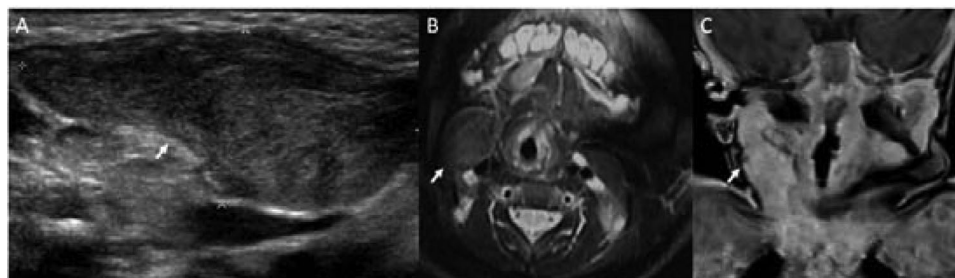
Sagittal US image (A), axial fat-suppressed T2-weighted (B), and coronal contrast-enhanced fat-suppressed T1-weighted (C) MR images of a child with *Fibromatosis colli*. The ultrasound image (A) demonstrates heterogeneous hyperechoic fusiform enlargement of the caudal part of the sternocleidomastoid muscle. A rim of normal peripheral muscle is shown. The axial MR image (B) reveals mild increased T2 signal intensity of the sternocleidomastoid muscle as well as mass effect on adjacent structures. The sagittal MR image (C) demonstrates contrast enhancement of the sternocleidomastoid muscle.
